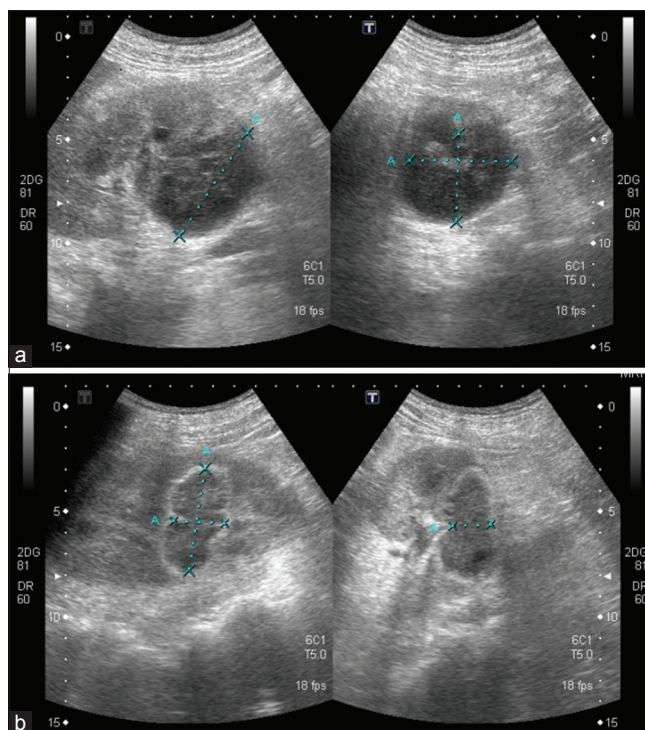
Ultrasound of the right (a) and the left (b) kidney with renal abscesses
